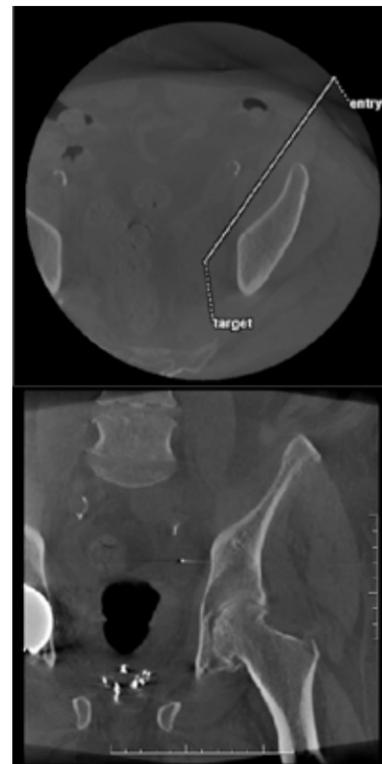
Planned entry and target positions from the cone beam CT.
